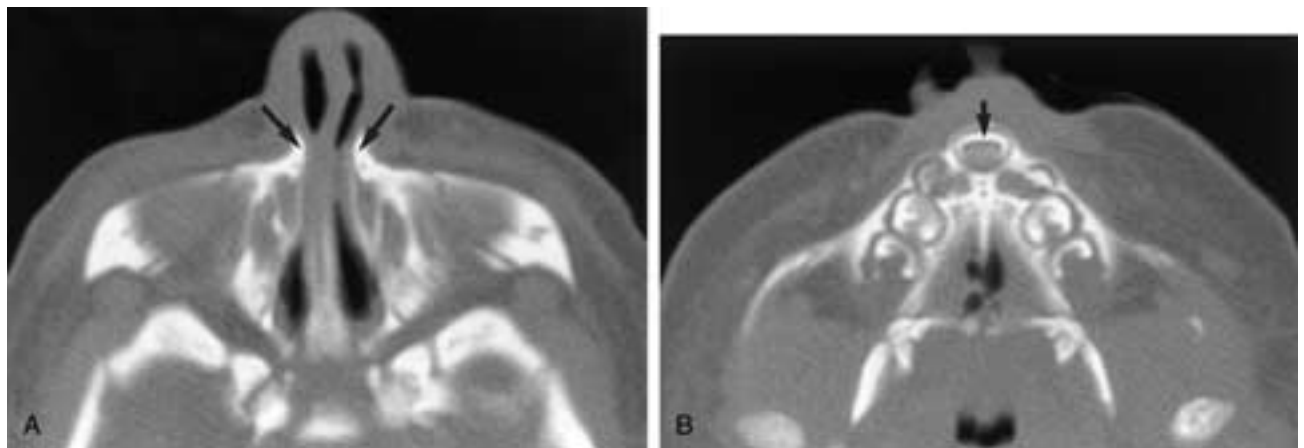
Bilateral pyriform aperture stenosis in a 2-day-old boy. Axial CT demonstrates (A) medial approximation of the nasal processes of the maxilla at the pyriform apertures (*arrows*). Contrast this appearance with the normal anatomy of the pyriform apertures in Figure 29-22. B, There is a single central megaincisor (*arrow*).
